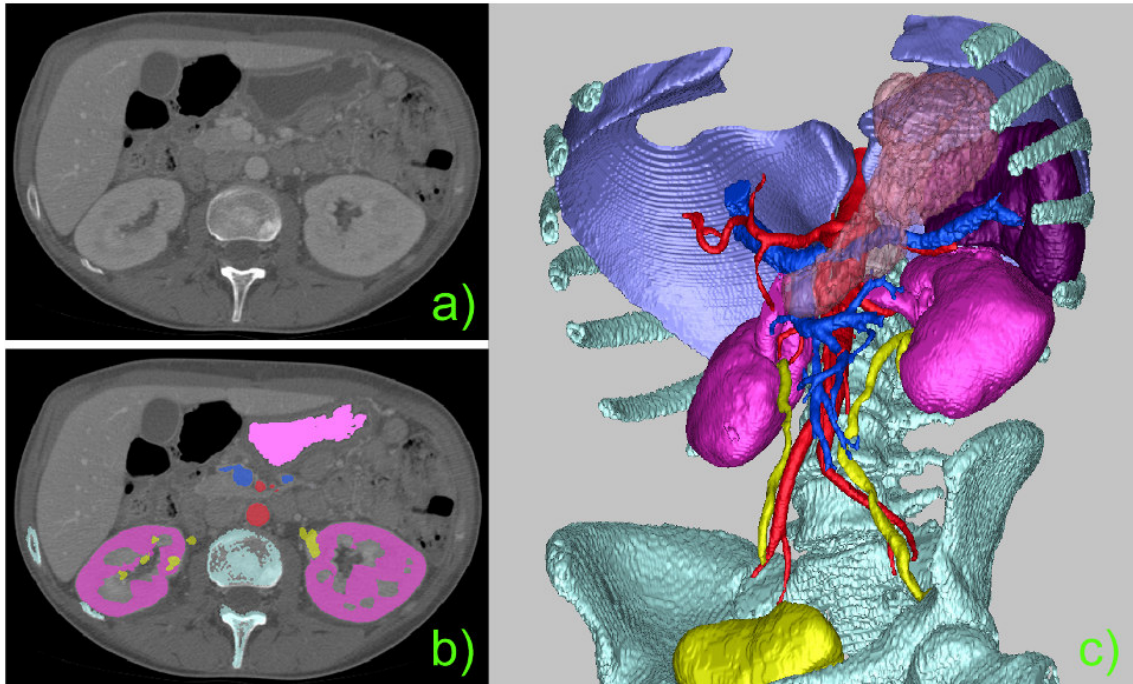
Modeling of anatomical structures: (a) CT dataset slice, (b) Segmentation and Labeling, (c) 3D surface models extracted from segmented and labeled images.
